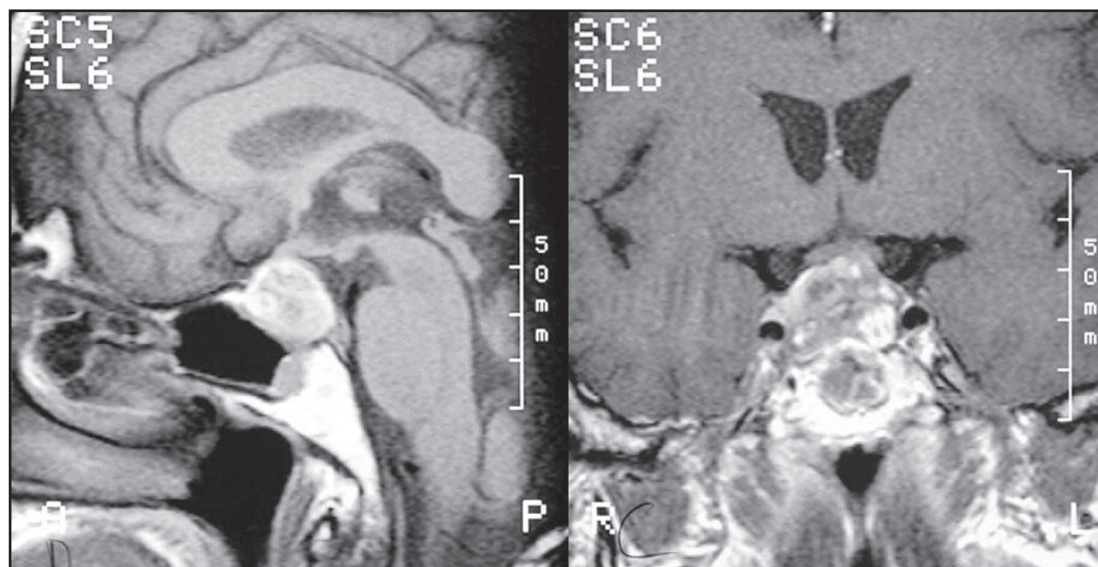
MRI of the sella turcica region - pathological mass corresponding to pituitary adenoma with internal hemorrhage and compression of the right cavernous sinus.
